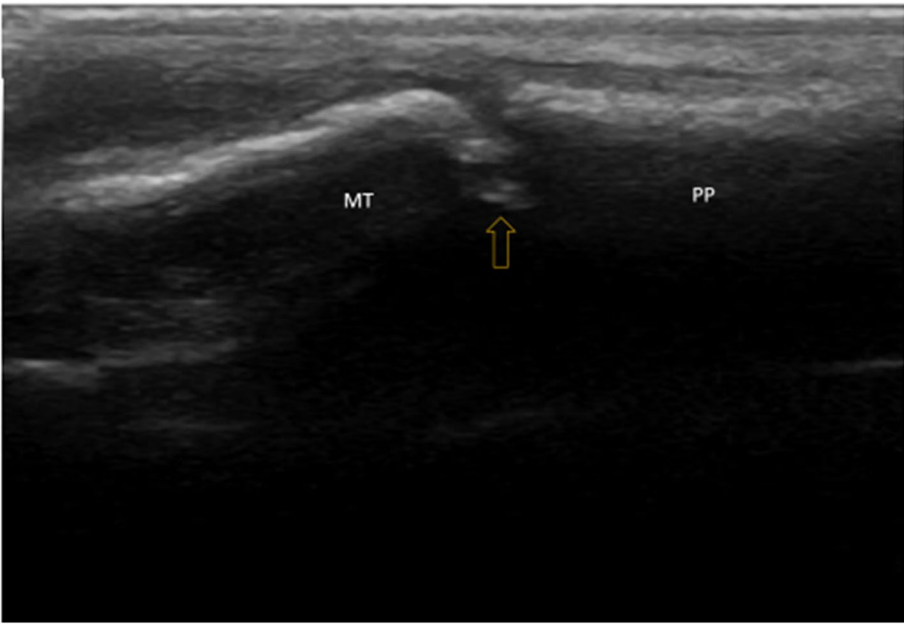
Dorsal longitudinal gray scale ultrasound scan of the first MTP joint showing erosion (arrow)
